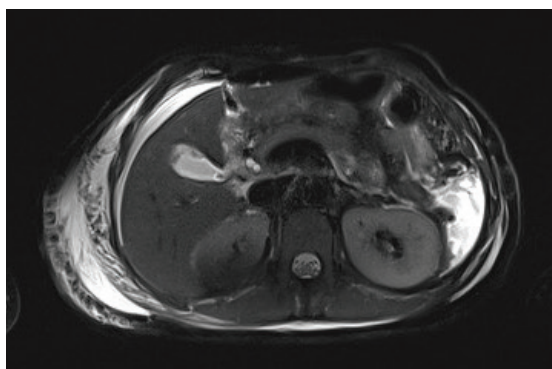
T2 FS axial image confirmed the CT finding of fluid collection in the gall bladder bed.
